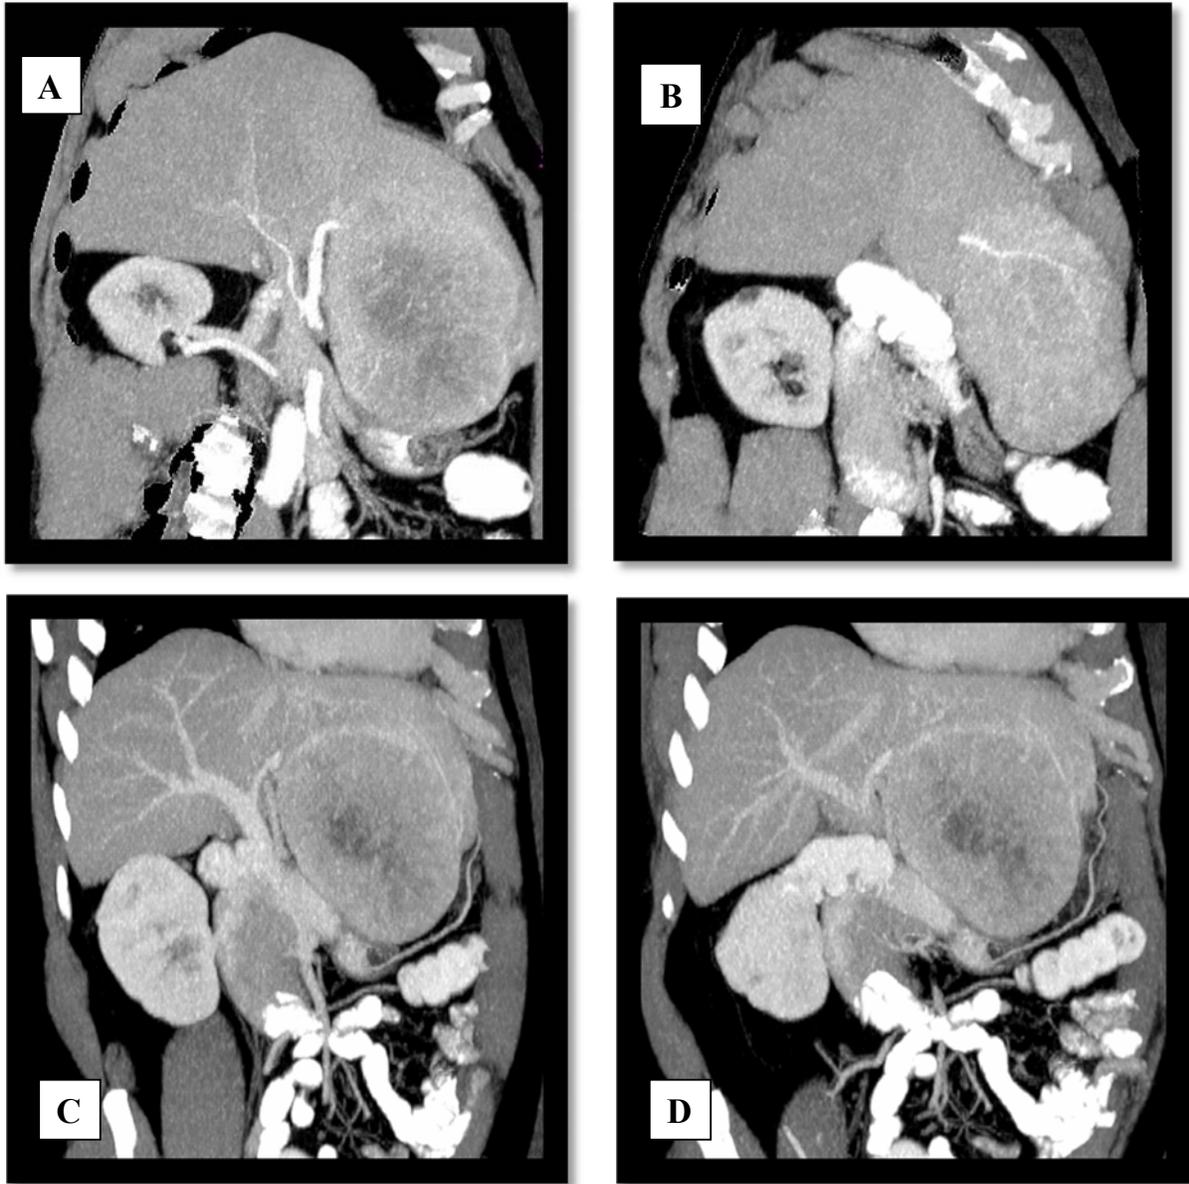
Reconstructed Dynamic Computed Tomography of the liver
